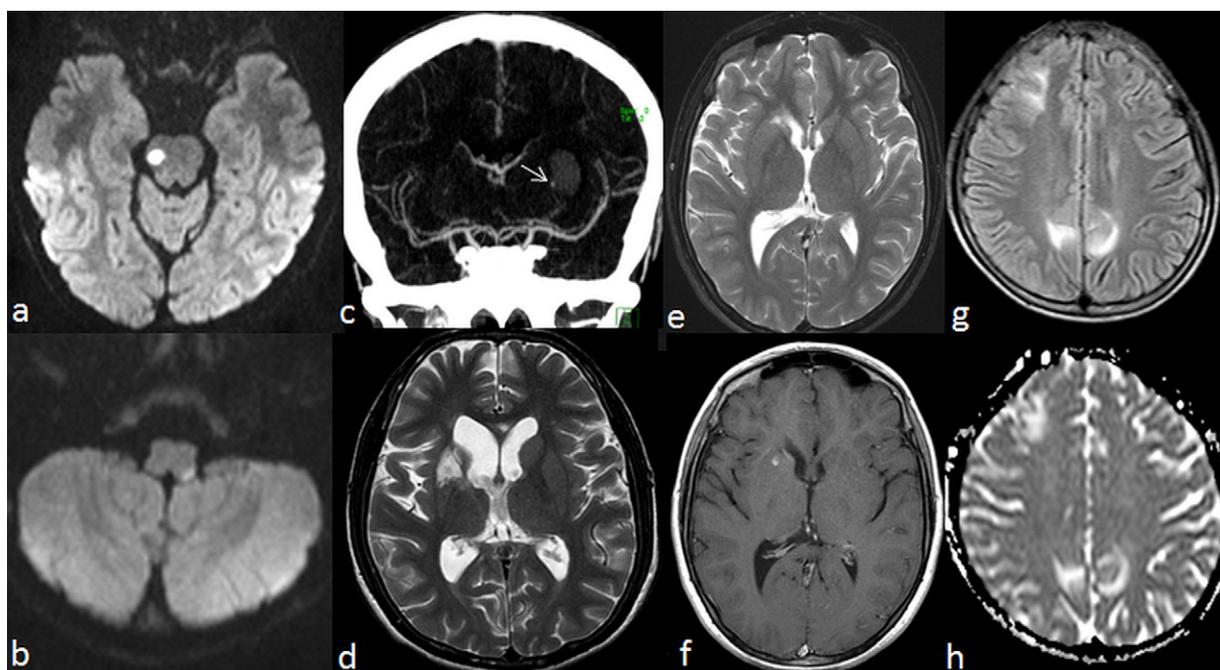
Brain MRI findings in DADA2 patients. The DWIs performed at the time of recurrent ischemic attacks show acute ischemic lesions located at the right lateral pontomesencephalic junction (a) and the left lateral medulla oblongata (b) in a patient (no. 12). The coronal reformatted CTA (c) of a patient (no. 5) demonstrates an acute hematoma in the left basal ganglion with a “spot sign” suggestive of active bleeding (arrow). Axial T2W image (d) shows chronic lacunar infarction and resulting volume loss in the right basal ganglion in a patient (no. 4). Axial T2W (e) and Post-Gd (f) images show abnormal milimetric contrast enhancement superimposed on previous changes in the right basal ganglion of a patient (no. 3). Axial FLAIR image (g) and ADC map (h) show subcortical hyperintense signal changes in bilateral posterior parietal and right frontal watershed areas compatible with PRES in a patient (no. 11).
